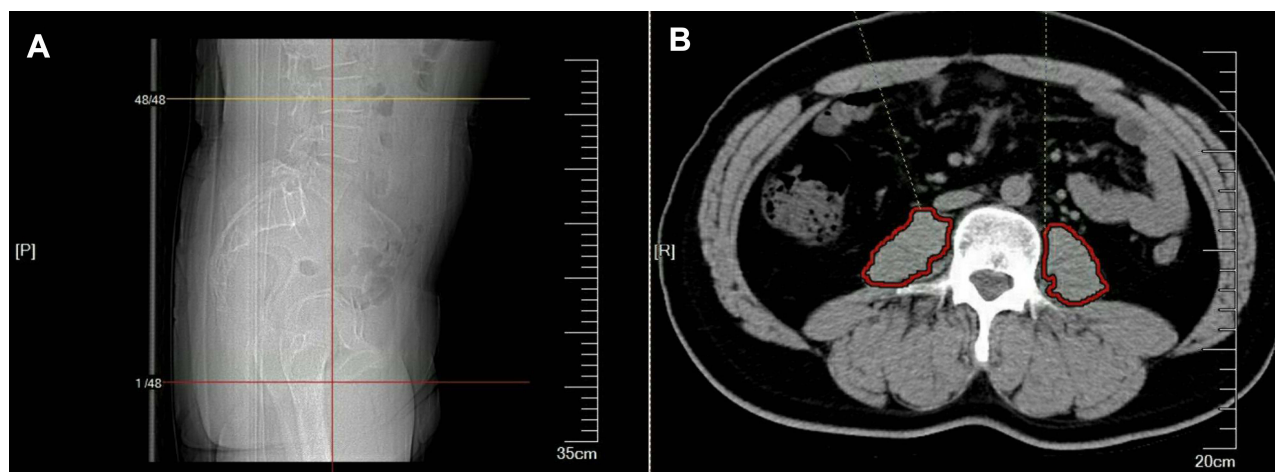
Computed tomographic images at the the middle third lumbar vertebral level. (A) Sagittal map. (B) Cross-sectional image and red circle shows the outline of psoas.
